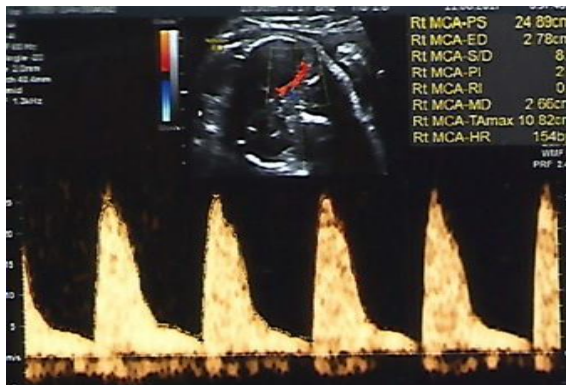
MCA Doppler of fetus
